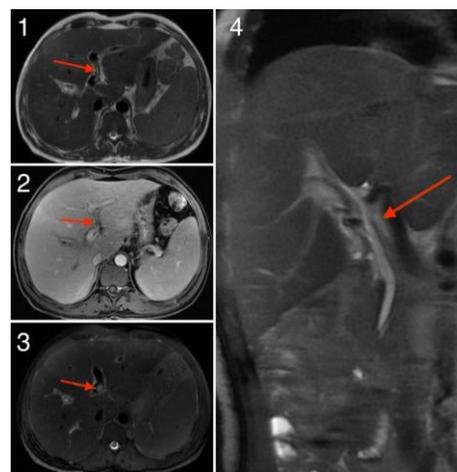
Contrast-enhanced MRI Abdomen and Pelvis – 1,3,4: Eccentric T2 hyperintense contents are seen in the portal vein extending into portal bifurcation and into both main lobar branches of portal vein with entire segments of right lobe of liver showing hypointense signal compared to the left; 2: T1 filling defect noted in the portal vein suggestive of presence of a thrombus (Red arrows mark the site of thrombus)
